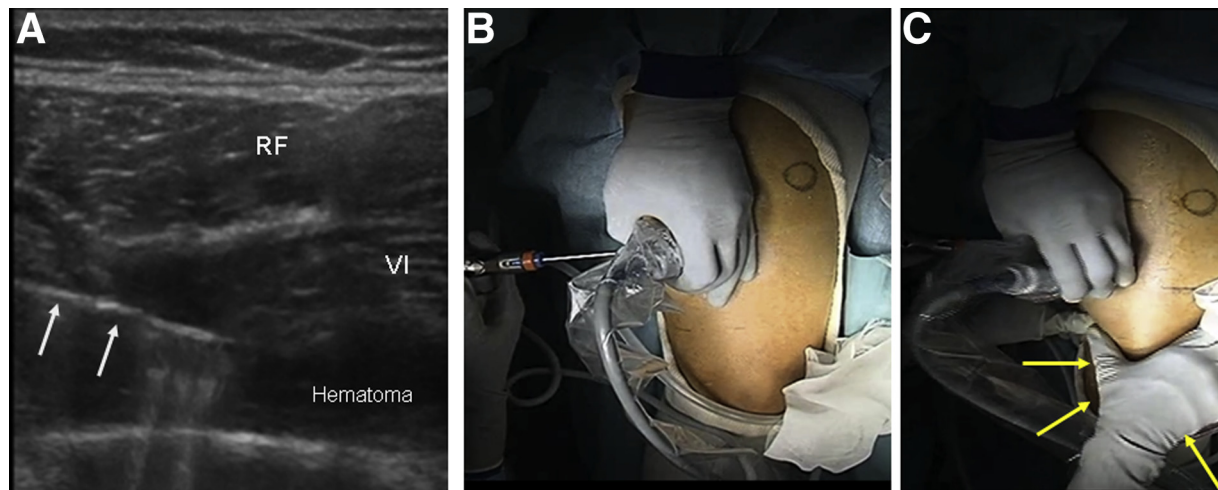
Ultrasound-guided muscle hematoma evacuation. (A) A shaver (white arrows) is introduced to the right thigh under ultrasound guidance to the center of the hematoma. The surrounding muscle tissues and neurovascular structures are avoided. (RF, rectus femoris; VI, vastus intermedius.) (B) The shaver is kept parallel to the US probe. (C) After removal of the hematoma at its center, the tip of the shaver as well as the US probe are synchronously brought to the peripheral part of the hematoma, and removal of the remaining hematoma is performed. A milking maneuver (yellow arrows) of the hematoma by an assistant is added to aid in the complete evacuation of the hematoma.
